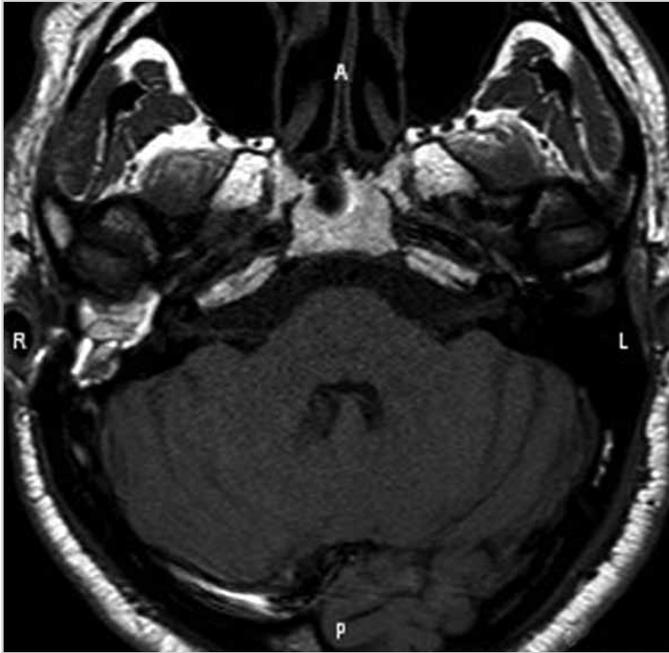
Postoperative MRI (T1-weighted) image of a patient who underwent cavity obliteration (hyperechogenic brightness associated with fat tissue draws attention)
